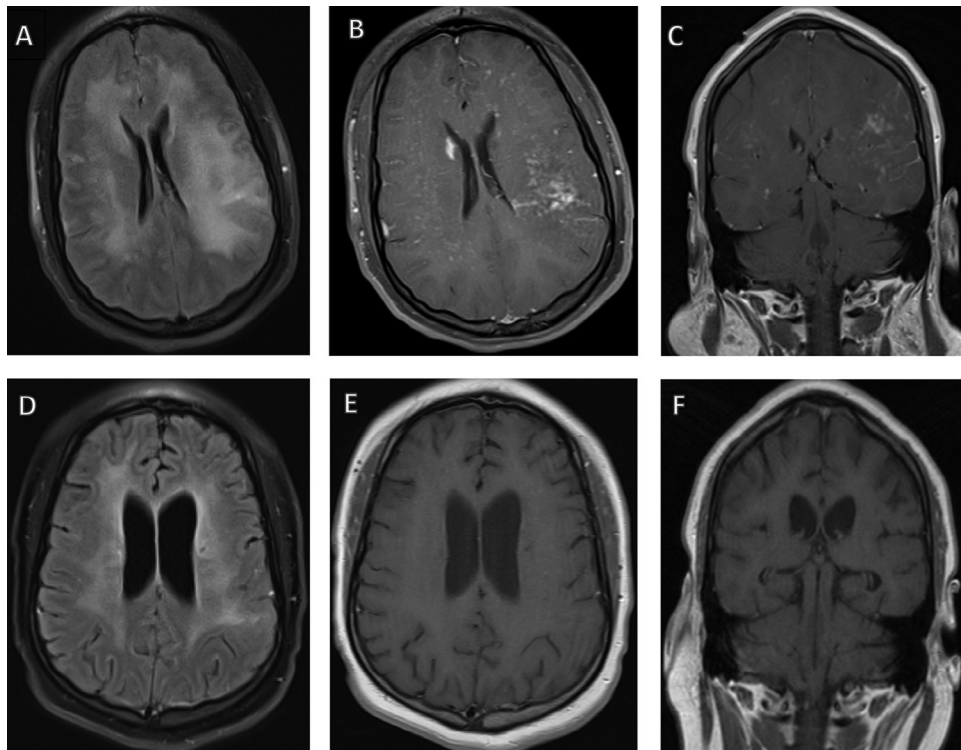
MRI brain before and after treatment. (A) T2 FLAIR sequence demonstrates extensive white matter T2 hyperintensities in the frontal, temporal, and parietal lobes. (B) Axial and (C) Coronal T1 postgadolinium show innumerable punctate and linear enhancing foci bilaterally within both cerebral hemispheres. Many enhancing lesions are perivascular in distribution, and there is leptomeningeal enhancement within several convexity sulci. (D) T2 FLAIR sequence improvement in the previously noted hyperintensities and (E) axial and (F) coronal T1 postgadolinium images shows no evidence of enhancement 20 months after cyclophosphamide and ABVD therapy.
